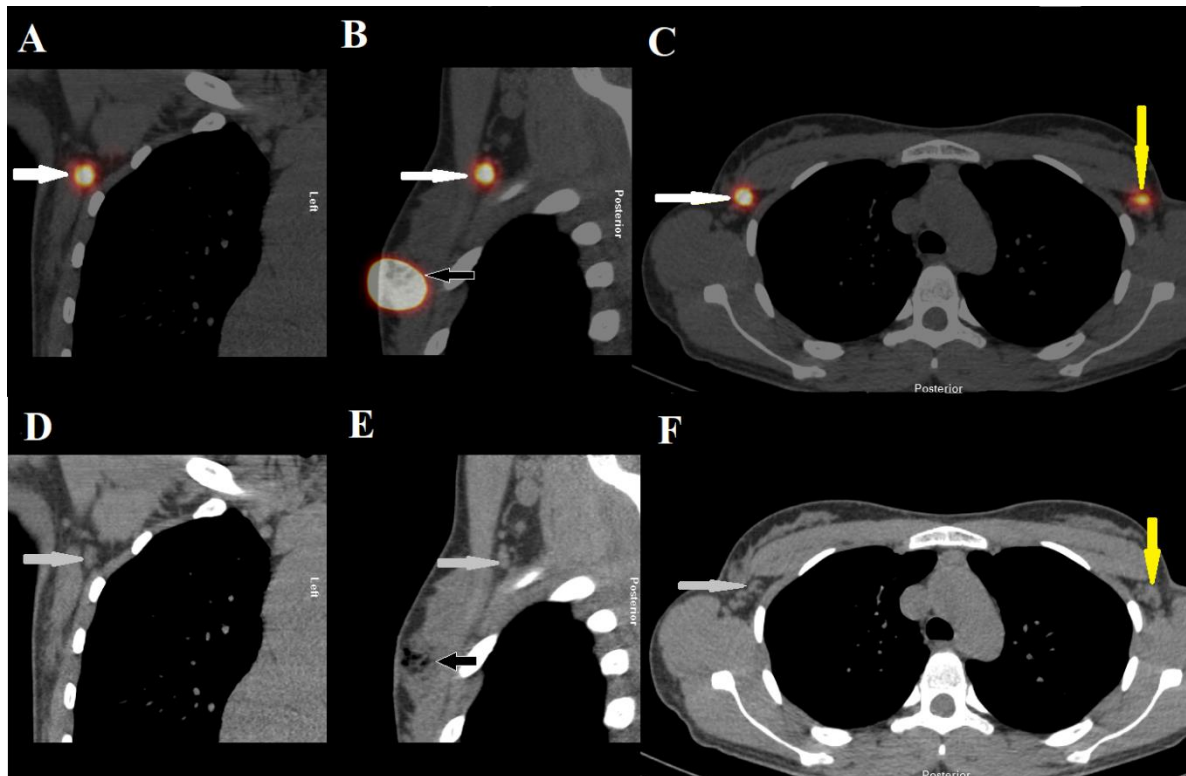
SPECT/CT images from a 45-year old woman undergoing bilateral pre-operative lymphoscintigraphy. Images A-C consist of fusion SPECT/CT images in coronal, sagittal and transversal orientation demonstrating SLN uptakes. Images D-F depict CT images in coronal, sagittal and transversal orientation. White arrows indicate SLN uptake in the right axilla. Grey arrows indicate corresponding anatomical location of the SLN in the right axilla. Yellow arrows indicate SLN uptake, as well as anatomical location of in the contralateral axilla. Black arrows indicate sites of injection with corresponding radiocolloid deposits and air bubbles.
